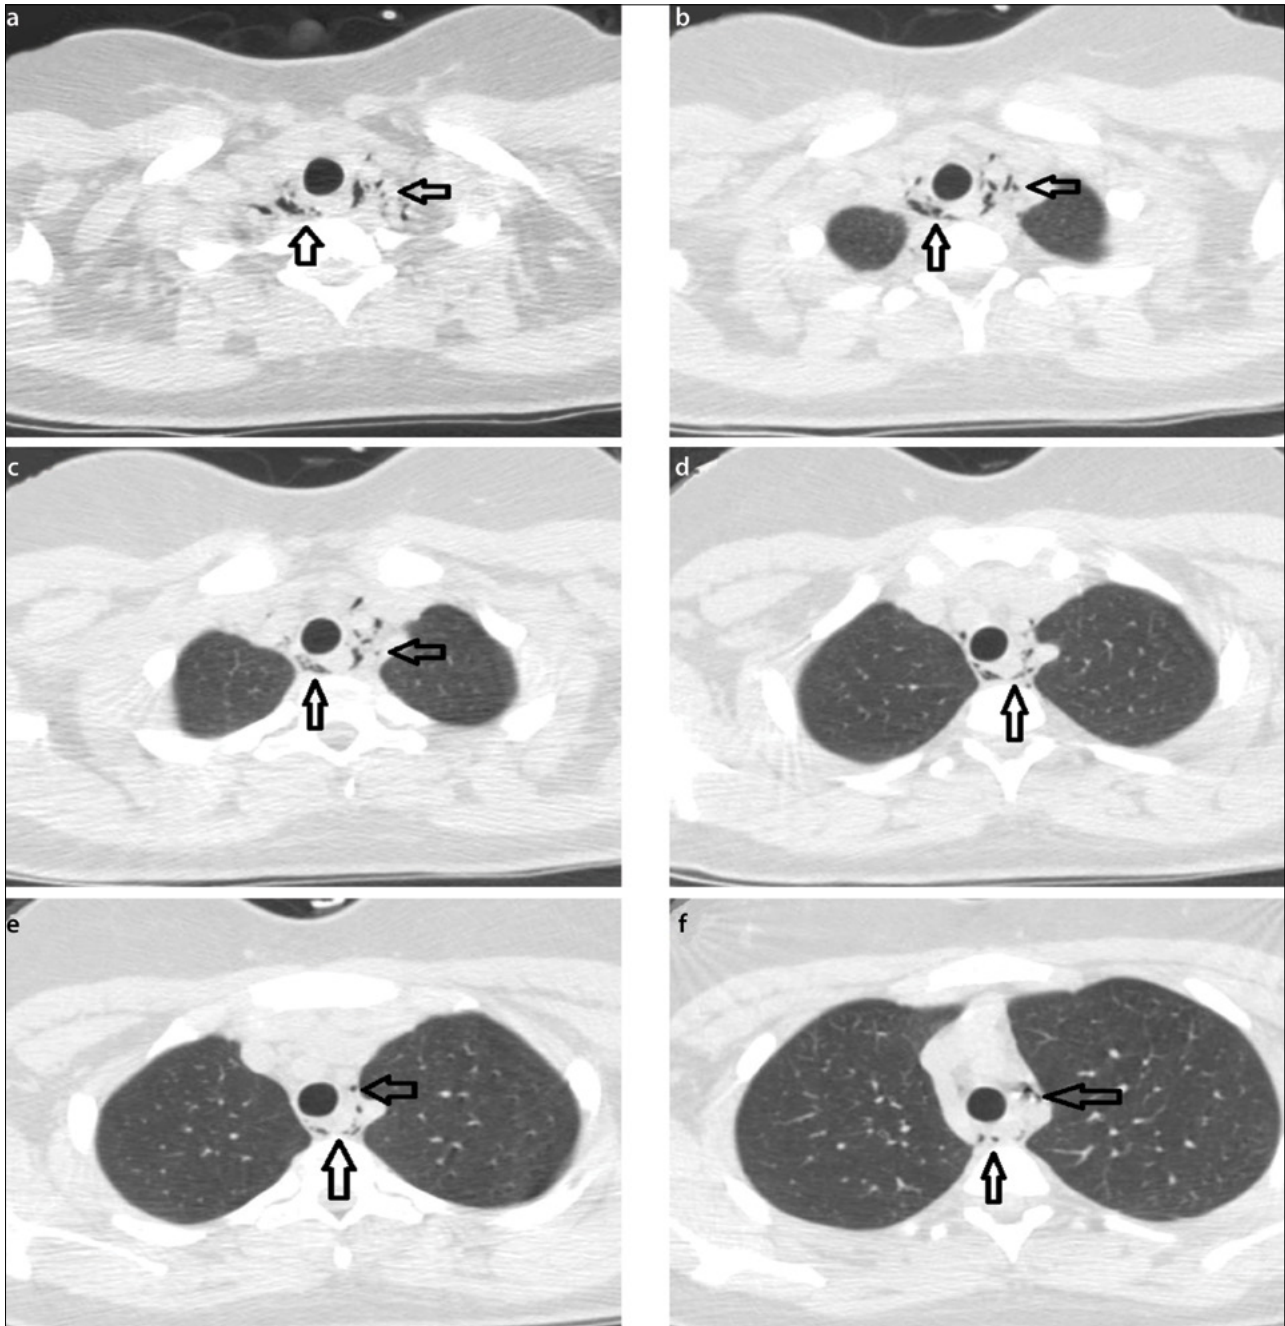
Axial plain computed tomography images (lung window) of the thorax. (a): thoracic inlet, (b, c): paratracheal, paraesophageal, and subcarinal (d-f): upper and posterior mediastinum demonstrate pneumomediastinum (arrows)
